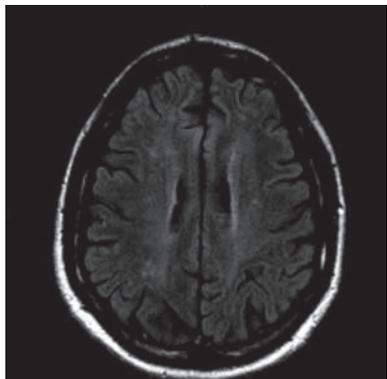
Axial T2-weighted FLAIR MRI from second presentation demonstrating increased white matter hyperintensities compared to the initial MRI (Figure 2).
